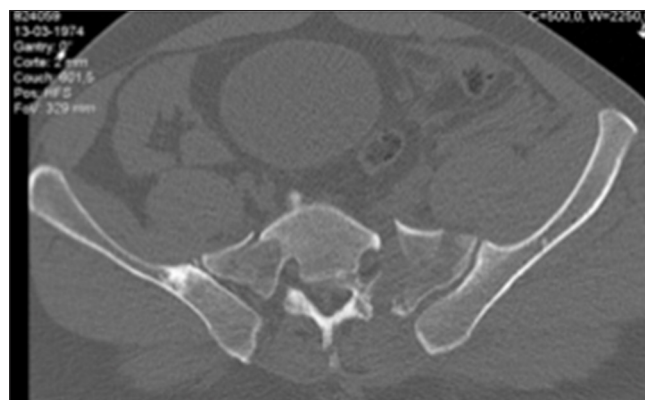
CT transversal view
